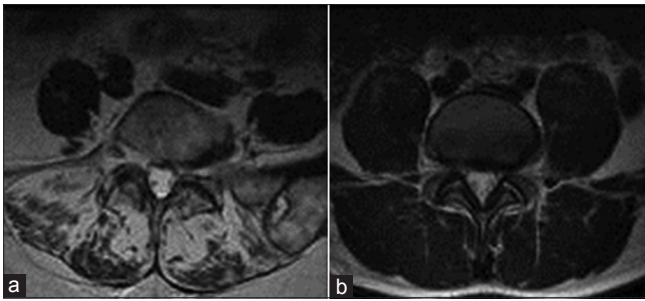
Axial T2 MR images at L5 of two patients from the current study. (a) Demonstration of Grade 4. (b) Demonstration of Grade 1
